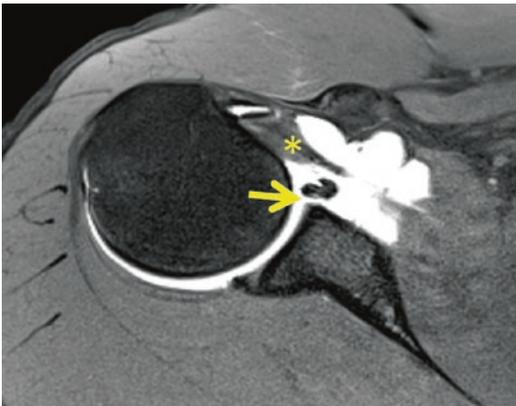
MRI arthrogram indicating enhanced visibility of a cord like MGHL (*asterisk*) and Buford complex—anatomic variant mimicking labral tear (*arrow*)
